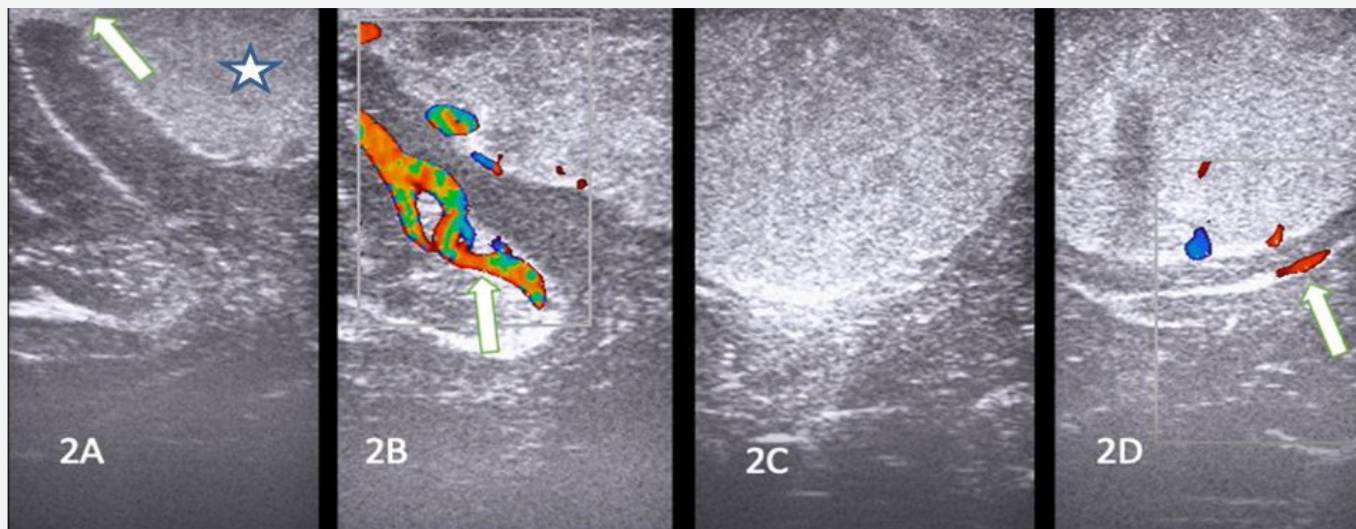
Transdural IOUS images of the same case after craniectomy. 2A: Dural thickening (white arrow), tumoral mass lesion image in the posterior (white star). 2B: In the USG of the same case, vascular structures adjacent to the tumor are observed in the intraoperative Doppler image (white arrow). 2C: Progression of the frontal part of the tumor pushing the brain parenchyma. 2D: Relationship with vascular structures in the frontal part
